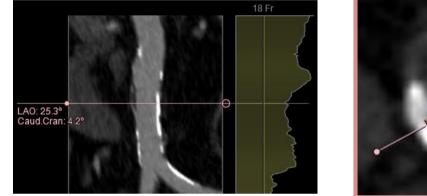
Figure CTA-9: Example of minimum abdominal aortic diameter. Stretched vessel (left), with the pink line at the location of the minimum luminal abdominal diameter. Orthogonal image (right), showing the minimum luminal diameter and the perpendicular diameter.
